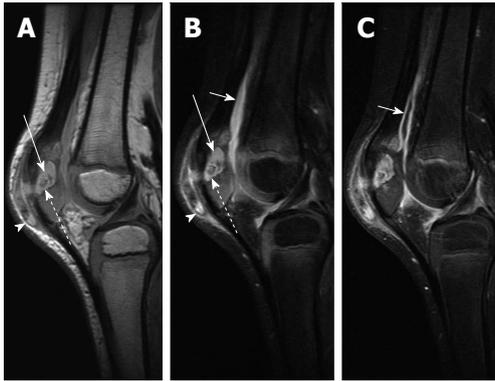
Chronic patellar osteomyelitis with abscess and sequestrum. A: Sagittal proton-density-weighted image of the right knee shows an abscess cavity in the patella (solid arrow) with a central low-density focus consistent with a sequestrum (dashed arrow). There is also disruption of the anterior cortex with spread of infection into the prepatellar bursa (arrowhead); B: Sagittal T2-weighted image with fat suppression again shows the intraosseous abscess (solid long arrow) with central T2 hypointense sequestrum (dashed arrow) and extension of infection into the prepatellar soft tissues (arrowhead). A knee joint effusion is more apparent on this image (solid short arrow); C: Sagittal T1-weighted post-contrast image shows enhancement of the synovium (solid short arrow) indicative synovitis, likely from intra-articular extension of infection.
